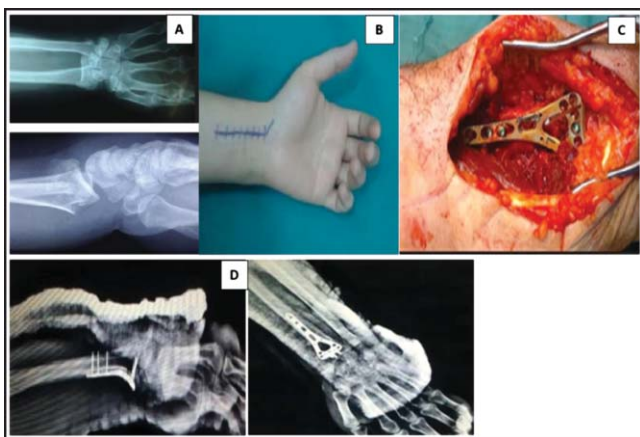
A and B) Pre-operative AP and lateral view X-ray of distal radius extra articular fracture. C) Skin incision marking FCR approach, D) post-op. X-ray with locked plate fixation. (Al Shahwanii, Qaryaqos. Al Yarmook Teaching Hospital 2017).
